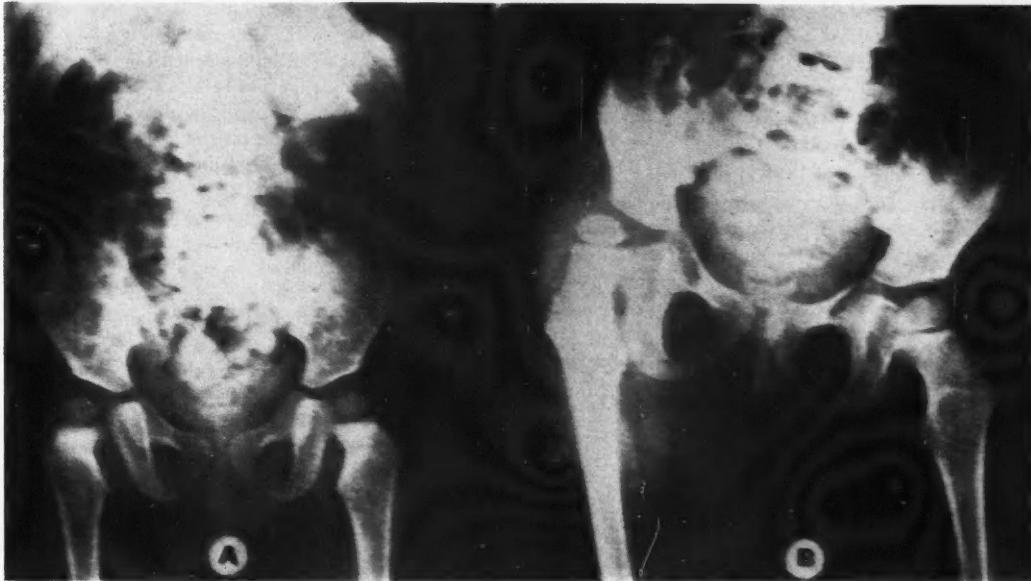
X-ray films of pelvis to show migration of femoral head. Tension athetoid cerebral palsy with subluxed right femoral head *A*, at age 1 year; *B*, at age 3½ years. Note: Valgus of femoral neck on right, 165°. Acetabular index normal.
